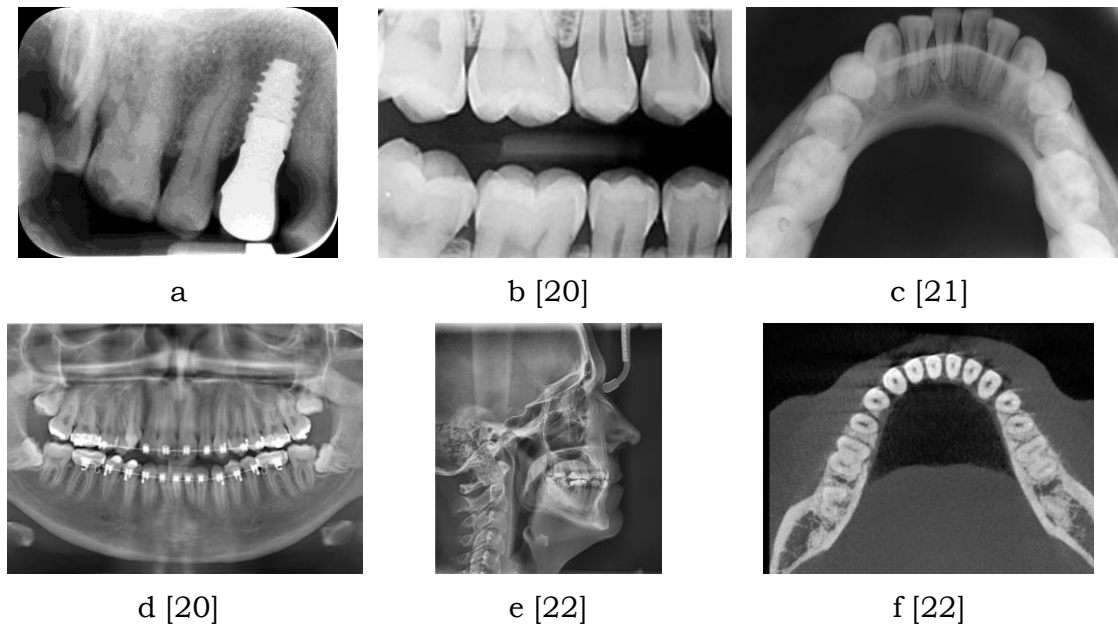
Dental X-ray Modalities. *a*, periapical. *b*, bite-wing. *c*, occlusal. *d*, panoramic. *e*, cephalometric. *f*, cbct
